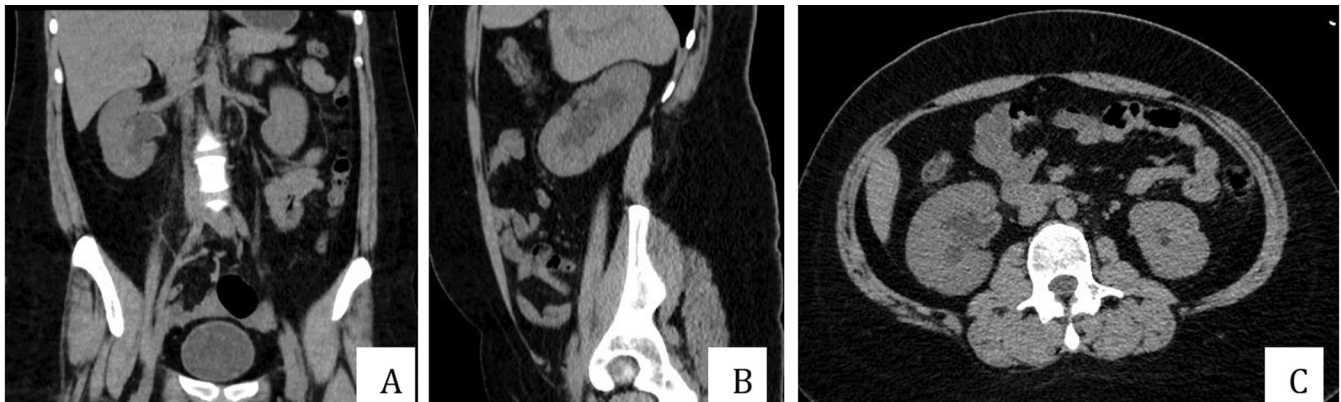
Plain CT scan findings of the patient. A) Coronal view of the right kidney with dilated right renal pelvis and proximal ureter. B) Sagittal view. C) Axial view.
